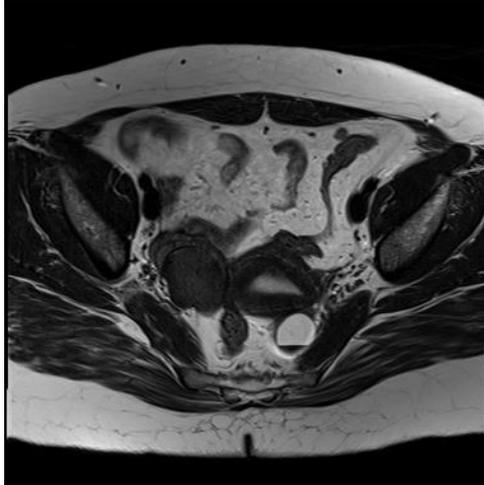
Axial plane T2-weighted image shows the hypointense right ovarian lesion and a hemorrhagic fluid level in one of the left ovarian follicles.
